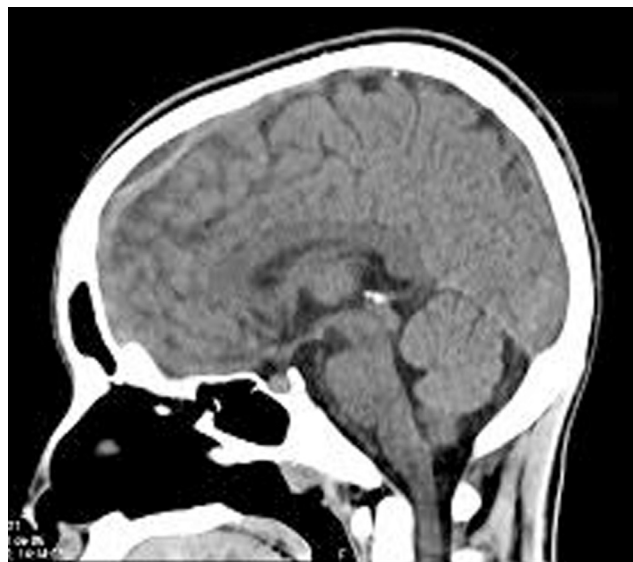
Sagittal computed tomography scan image showing the spontaneous epidural hematoma.
